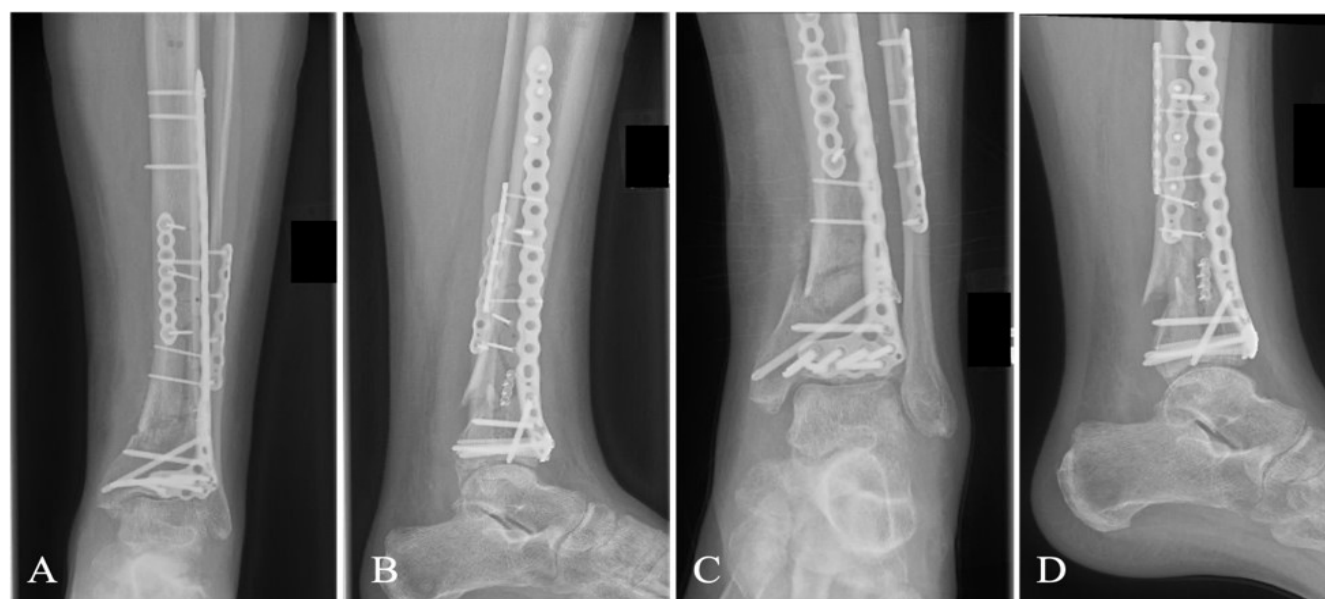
Four month post-operation pre-ambulation radiographs of the left ankle including (A) anteroposterior and (B) lateral views demonstrating well maintained tibial alignment and intact hardware but minimal further healing of the tibial metaphysis. Four month post-operation post-ambulation radiographs including (C) anteroposterior and (D) lateral views demonstrating acute displacement of the tibial fracture with apex anterior angulation, hardware intact.
